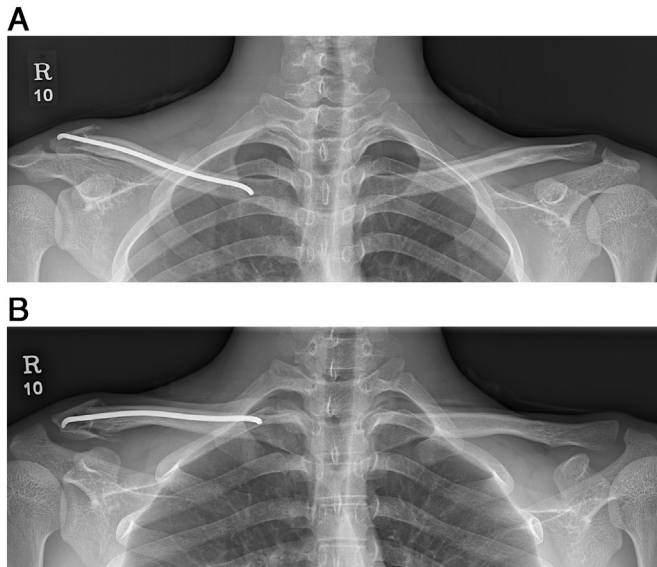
Postoperative anteroposterior (A) and lodontic (B) radiographs of the both clavicle. The distal fracture of right clavicle was fixed with a TEN.
